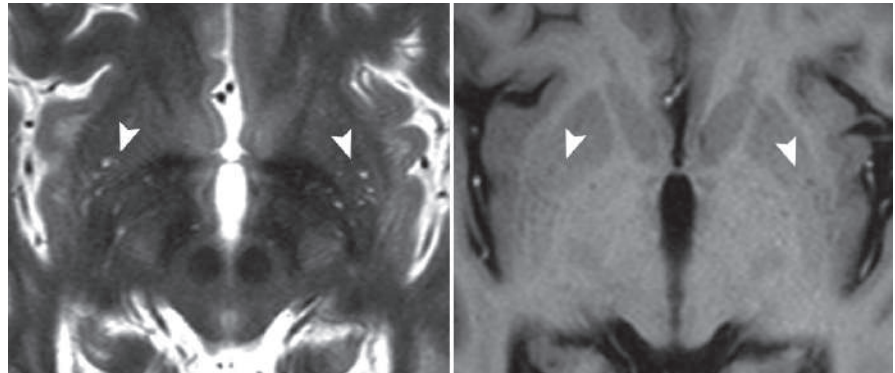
Coronal T2W (a) and T1W (b) MRI shows Virchow-Robin spaces dilatation surrounding the perforating arteries (état criblé) (arrowheads)
